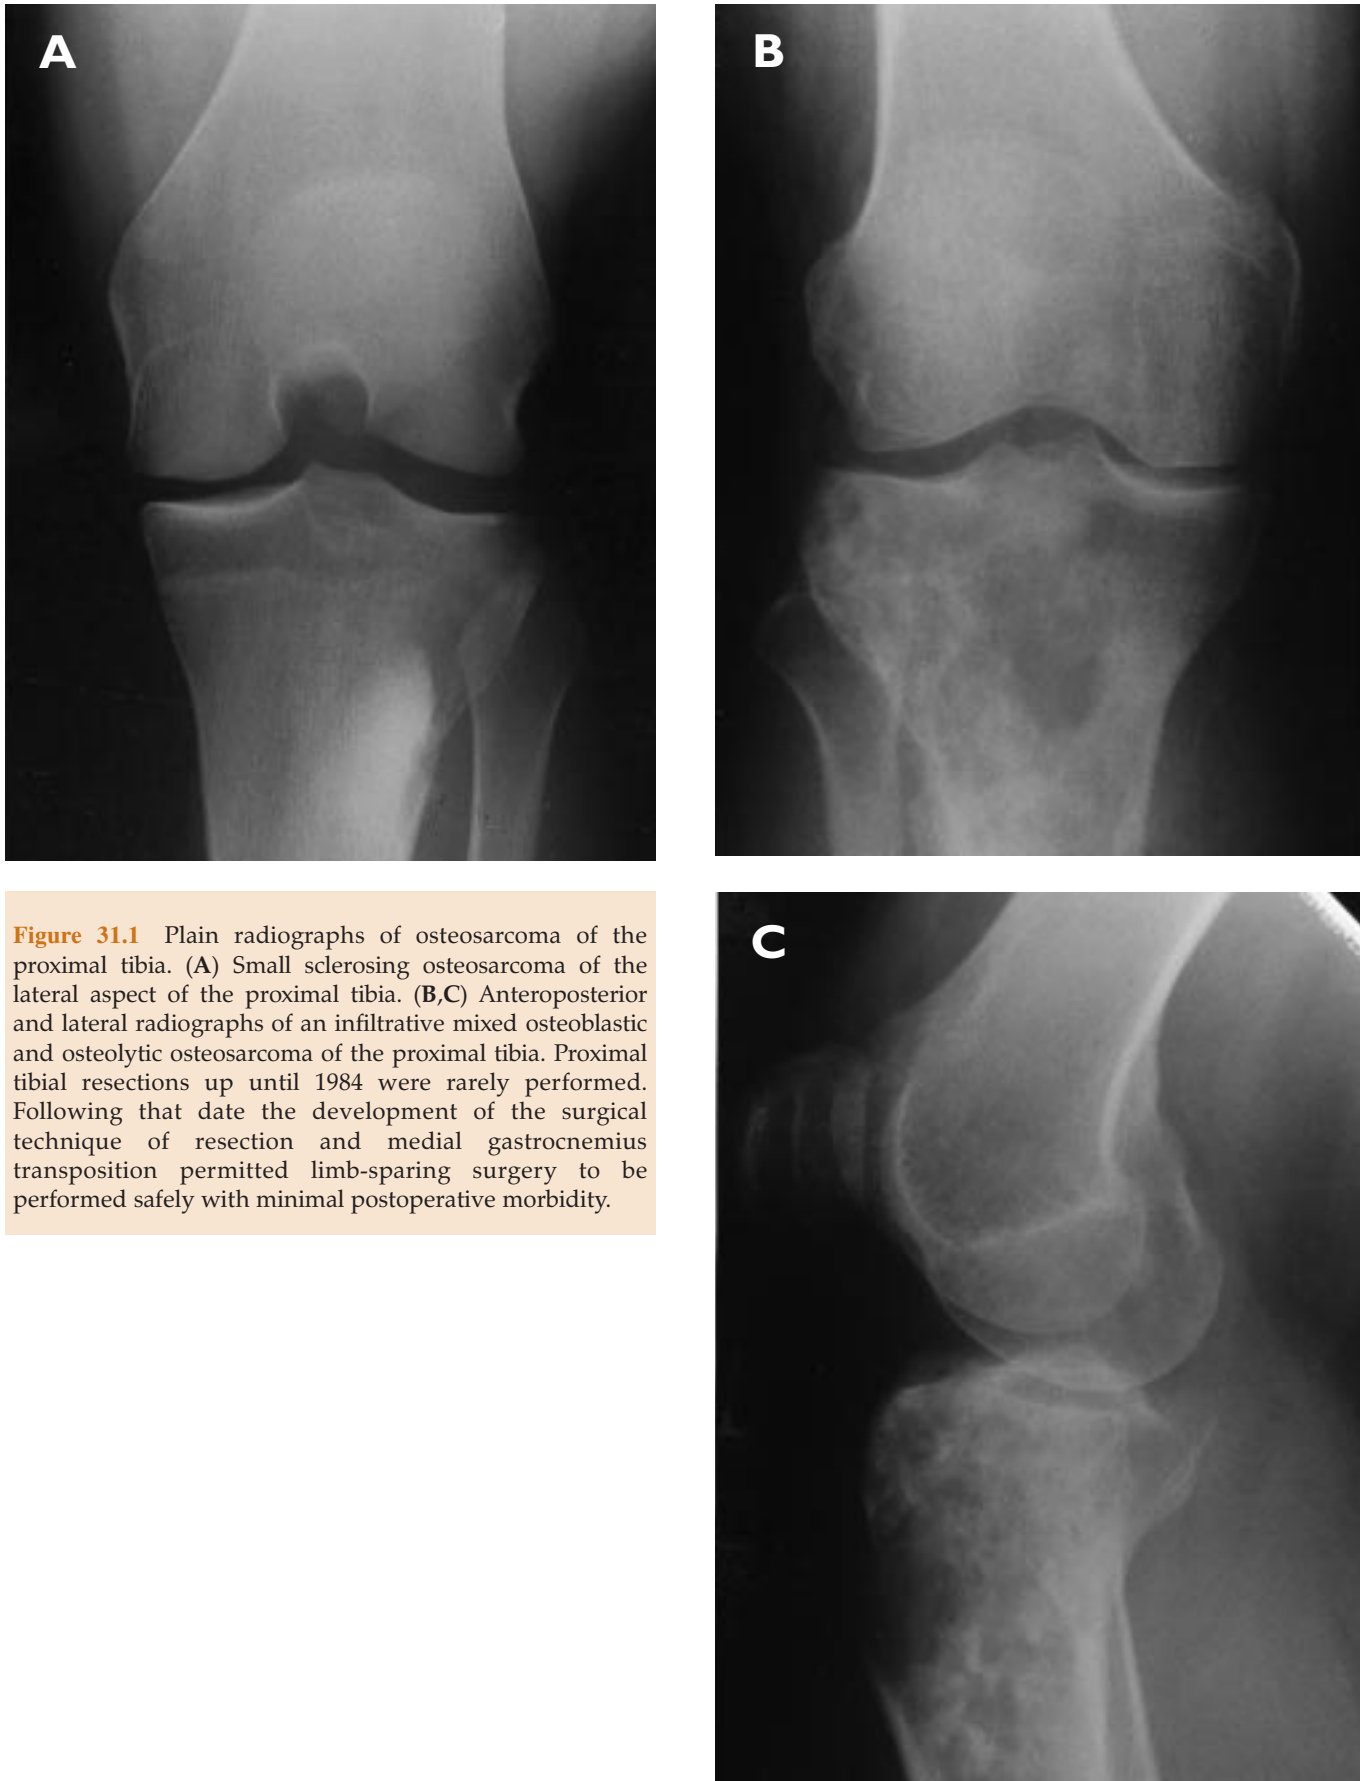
Plain radiographs of osteosarcoma of the proximal tibia. (A) Small sclerosing osteosarcoma of the lateral aspect of the proximal tibia. (B,C) Anteroposterior and lateral radiographs of an infiltrative mixed osteoblastic and osteolytic osteosarcoma of the proximal tibia. Proximal tibial resections up until 1984 were rarely performed. Following that date the development of the surgical technique of resection and medial gastrocnemius transposition permitted limb-sparing surgery to be performed safely with minimal postoperative morbidity.
